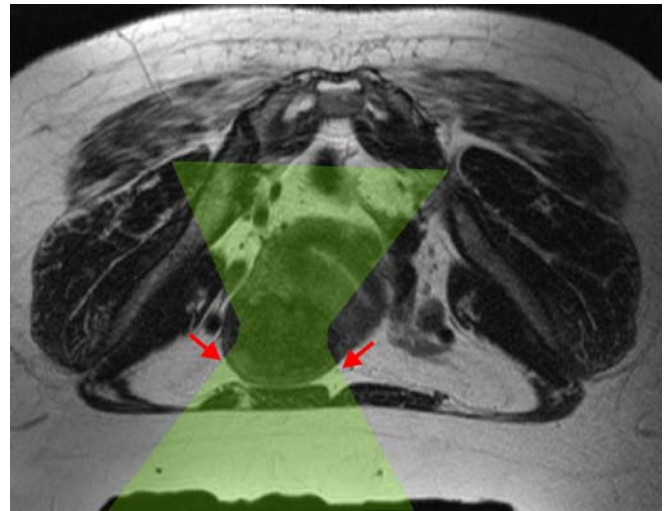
T2-weighted images of a patient with bowel in the beam path. a Shows a retroverted uterus and a large amount of bowel (marked with an arrow) interposed between the uterus and the abdominal wall. In b the patient had rectal fill (marked with an arrow) in order to push the uterus anterior, thus pushing bowels away from the beam path. In c the patient had bladder fill (marked with an arrow) in order to directly push bowels away from the beam path. The ultrasound beam path is not passing through bowels (highlighted on the image in green)
